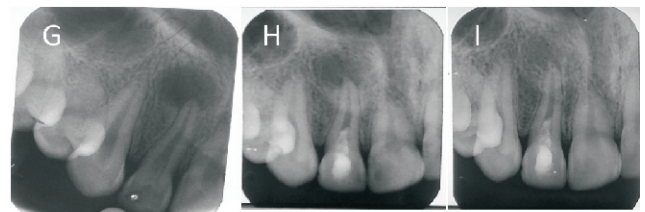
(G) Pre-treatment radiograph of the maxillary right lateral incisor showing a large well-defined periapical radiolucency at the apex. (H) Periapical radiographs obtained at the 6 months follow-up, shows evidence of healing after REPs. (I) Periapical radiograph obtained after 18 months, the periapical radiolucent lesion was completely healed. Tooth was asymptomatic and not responded to pulp sensibility tests.
